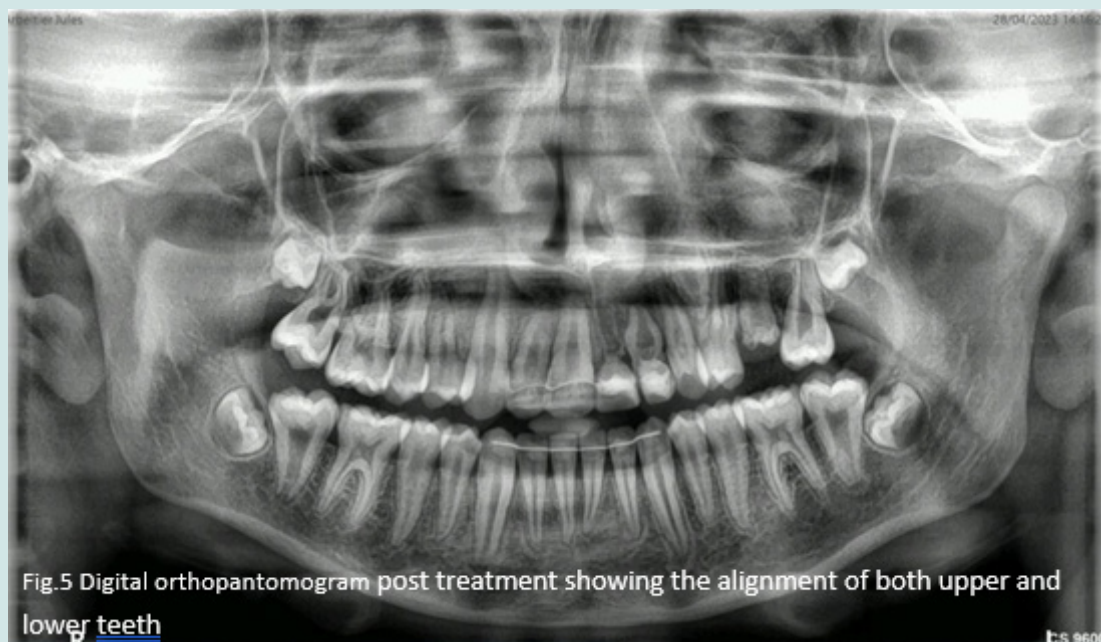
Digital orthopantomogram post treatment showing the alignment of both upper and lower teeth.
